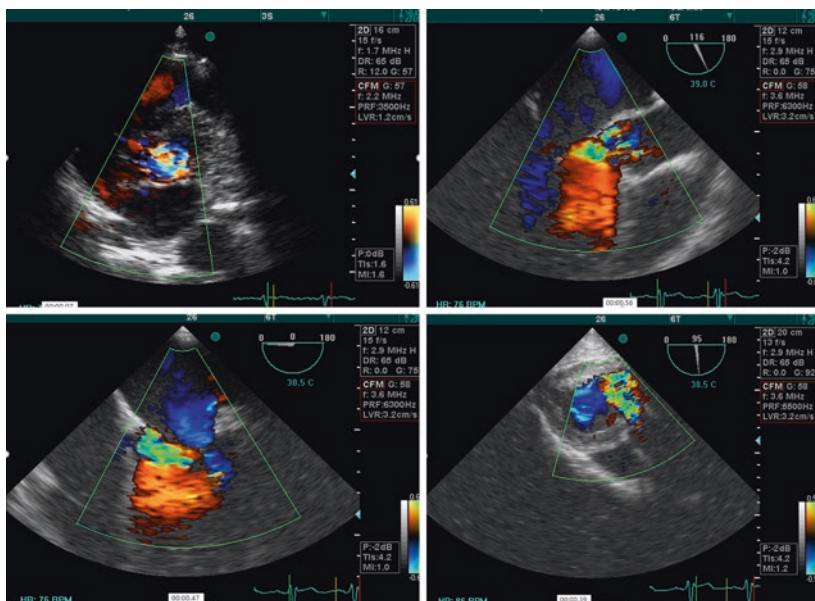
Severe multi-jet AI due to destroyed and perforated bicuspid aortic valve because of IE. Upper left: Parasternal short-axis view; Upper right: TEE, ME, 120° view; Lower left: TEE, ME, 0° view; Lower right: TEE, Trans-gastric, 90° view
